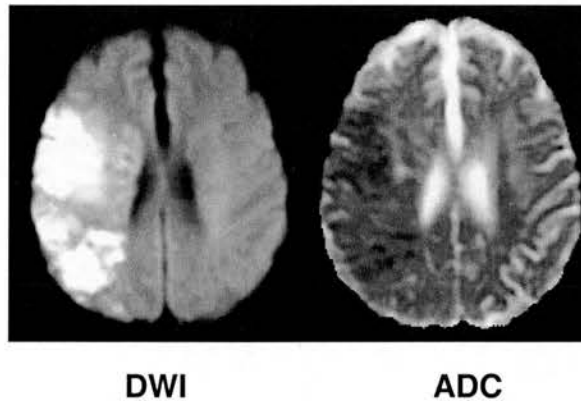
DWI and ADC image of a patient with a right hemisphere ischaemic lesion at 22 hours after stroke onset.
